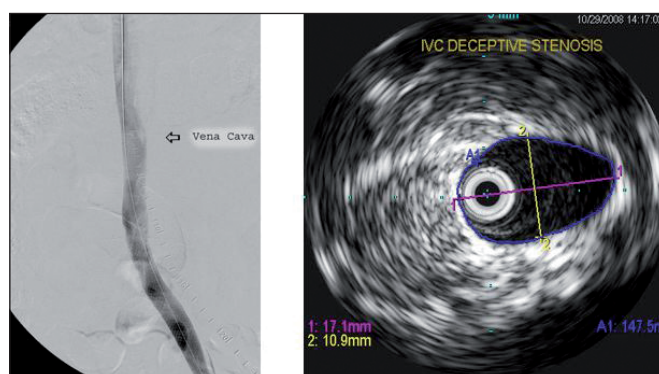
Phlebography and intravascular ultrasound of inferior vena cava (same patient)
